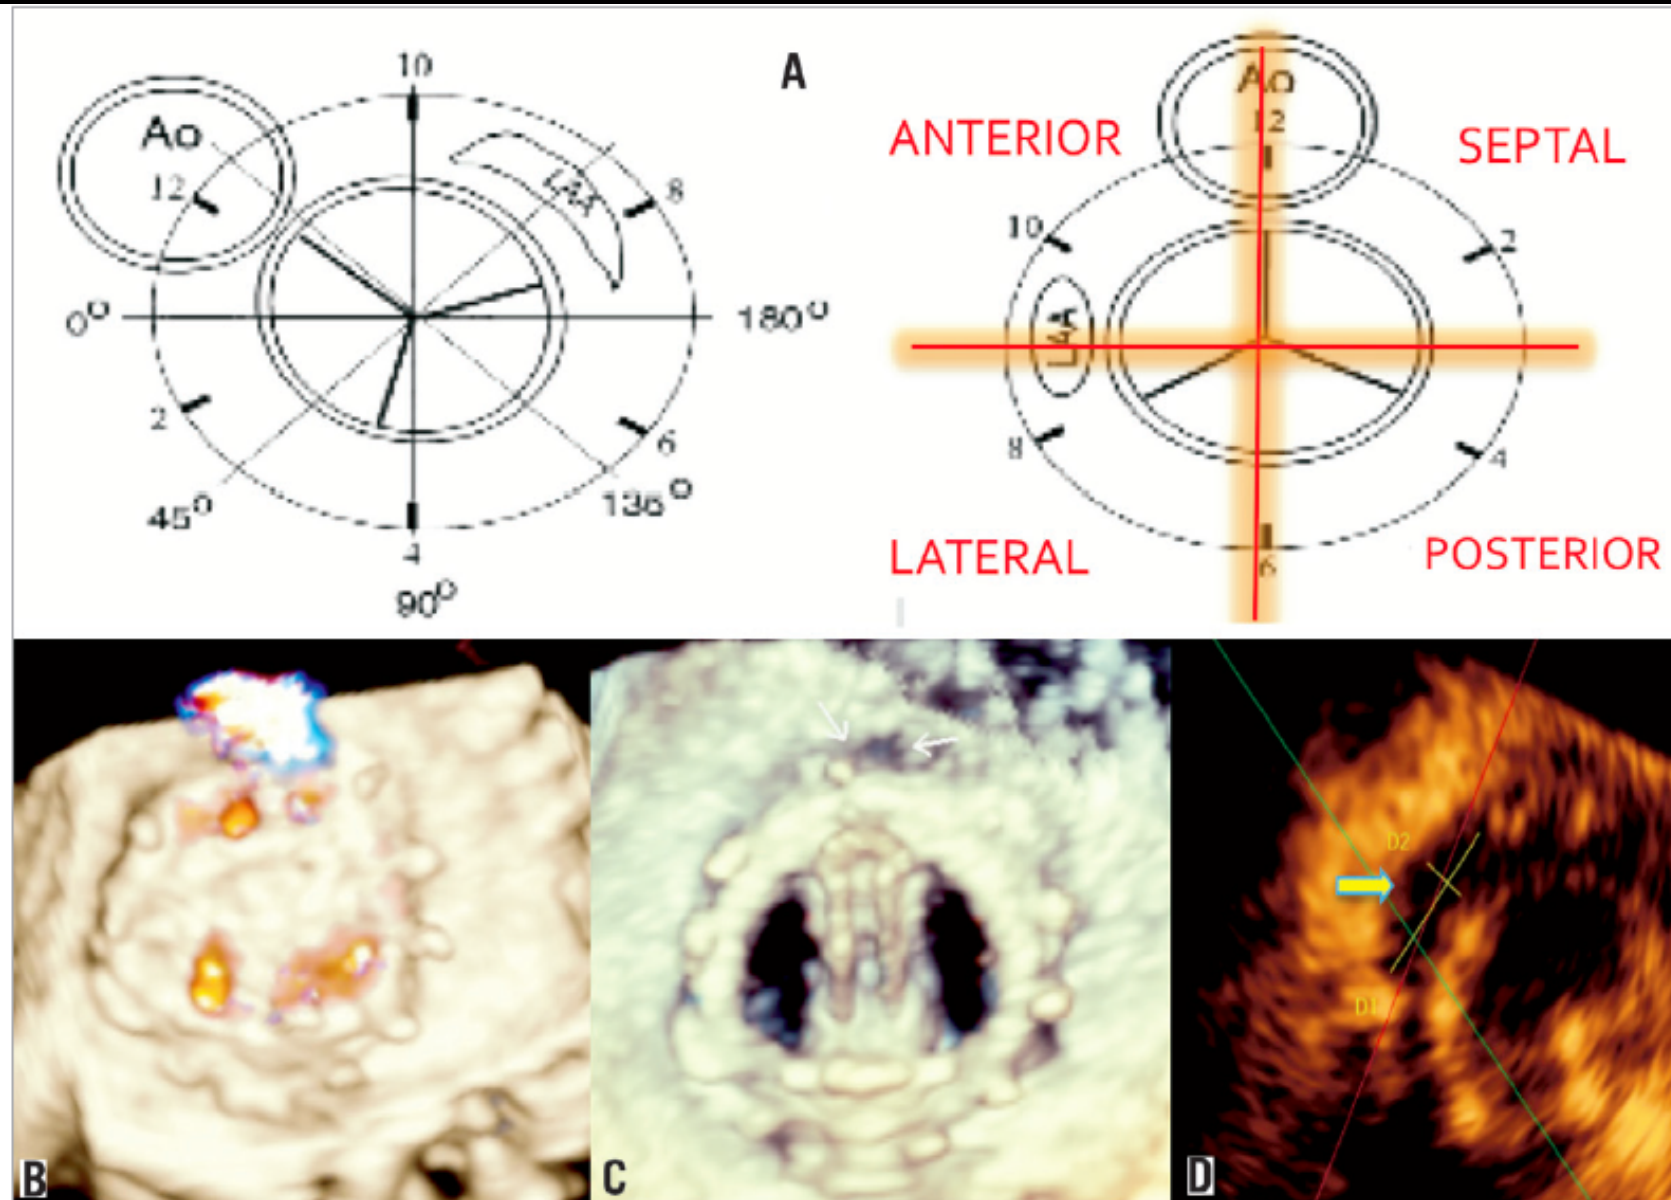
Mitral valve prosthetics, echocardiographic description of locations. A) Localisation of leaks, defects related to the aorta and left atrial appendage³¹. B) and C) show 3-D TEE of a mitral prosthetic valve as well as leaks in the anterior-septal position 0°. D) Estimating the leak size.
